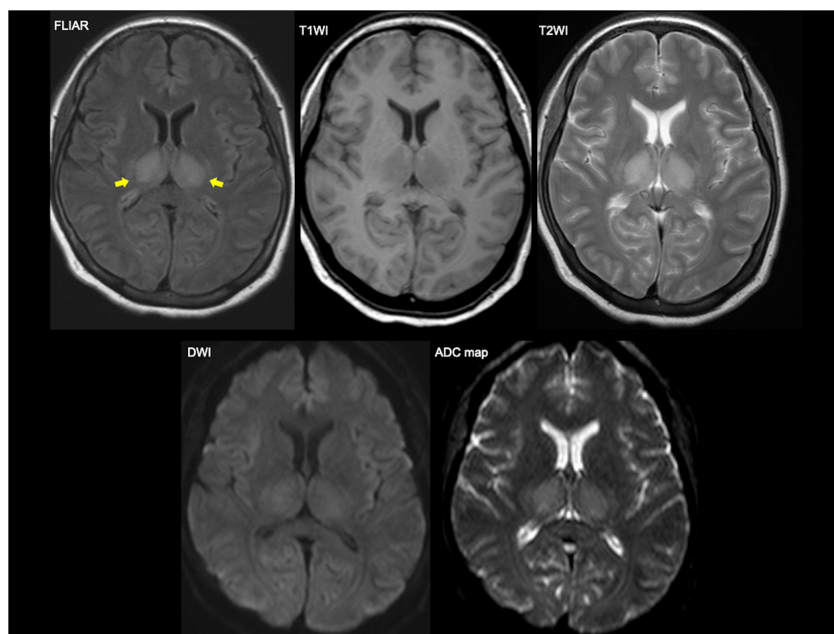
Magnetic resonance imaging (MRI) shows bilateral symmetrical thalamic involvement. These lesions demonstrate hypointense on T1-weighted image (WI), and hyperintense on T2WI and fluid attenuated inversion recovery sequence. Diffusion-weighted imaging demonstrate diffusion restriction in thalami, and axial apparent diffusion coefficient (ADC) images show trilaminar appearance.
